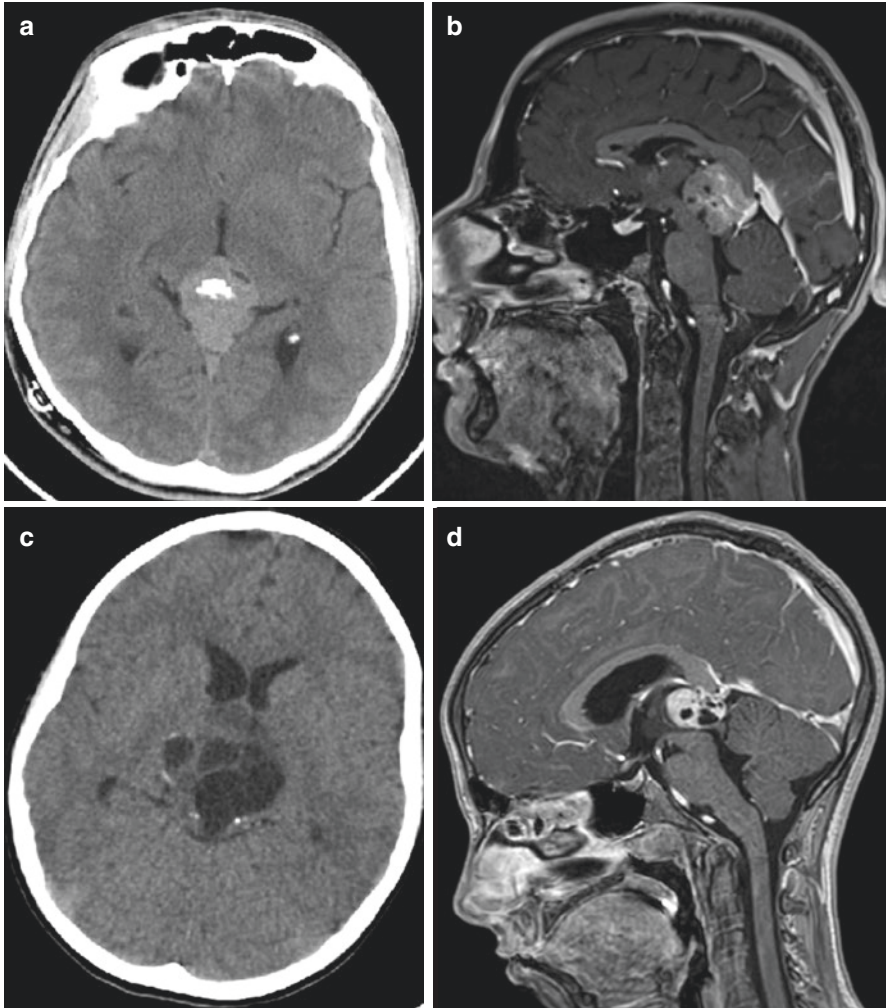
Computed tomography (a) and Magnetic resonance imaging (b) (T1WI after contrast delivery) of a pineal region germinoma. Computed tomography (c) and Magnetic resonance imaging (d) (T1WI after contrast delivery) of a pineal region teratoma
